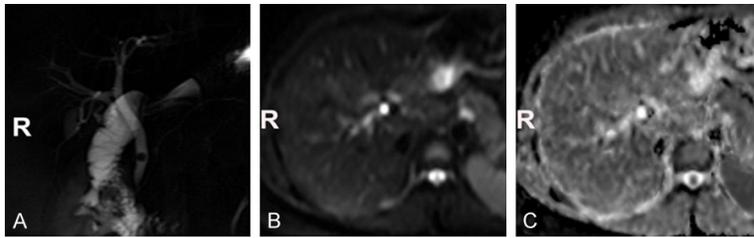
A 59-year-old female patient who had abdominal pain because of CBD stones. TBIL=108.8 $\mu\text{mol/L}$, DBIL=89.3 $\mu\text{mol/L}$, IBIL=19.5 $\mu\text{mol/L}$, ALT=330 U/L, AST=330 U/L, γ -GGT=127 U/L, ALP=128 U/L. A. MRCP shows that there was a stone in the lower segment of the common duct and bile duct in the liver didn't dilate significantly; B. DWI ($b=800 \text{ s/mm}^2$) did not show significant hyperintensity by naked eyes; C. Apparent diffusion coefficient map show that signal intensity of liver parenchyma seems reduced diffusely. After ADC measurements, mean ADC values of eight segments: $\text{ADC}_{\text{mean}}=1189 \text{ mm}^2/\text{s}$ (Normal ADC > 1249 mm^2/s).
